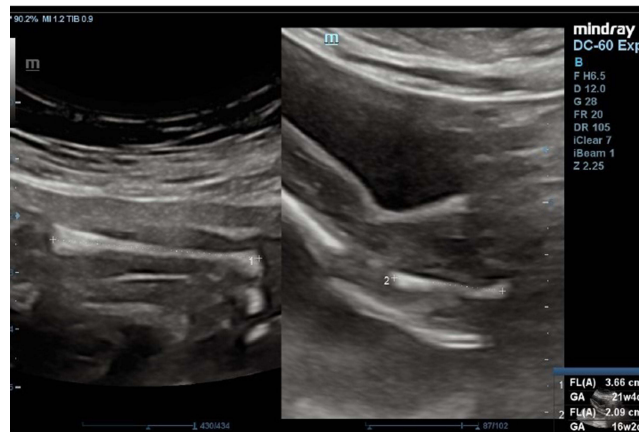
Dual-mode ultrasound of the femurs in a 22wk fetus complicated with PFFD. The left femur measures 20.9 mm, which is below the 1st percentile for gestational age, and the proximal epiphysis is not visualized. However, the right femur measures 36.6 mm, corresponding to the 53rd percentile for GA, and appears normal.
